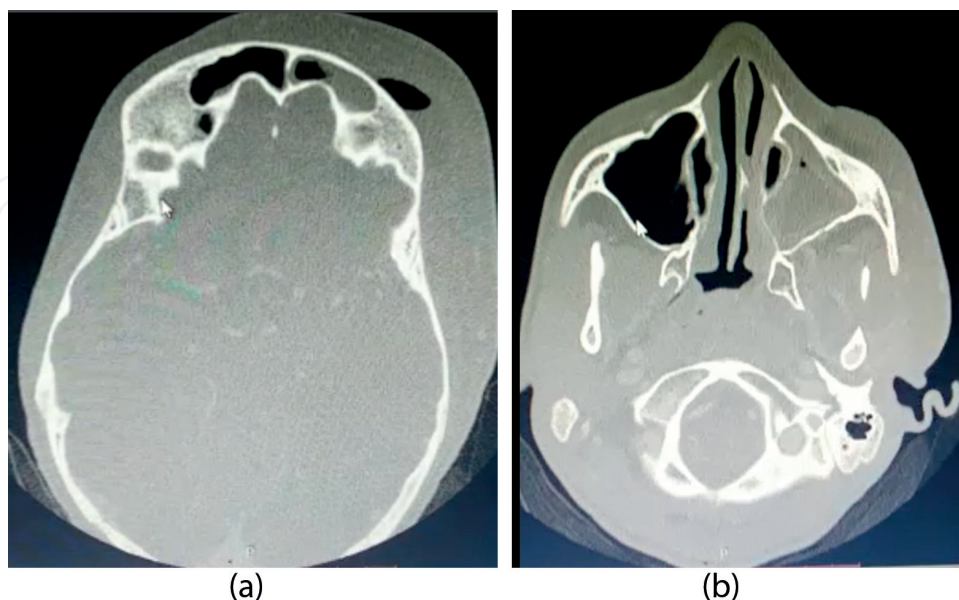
(a) Axial CT scan showing left frontal sinusitis associated with swelling of the left side of the face and air in the soft tissues. There is associated mild mucosal thickening in the right frontal sinus. (b) Axial CT scan showing left maxillary sinusitis.
